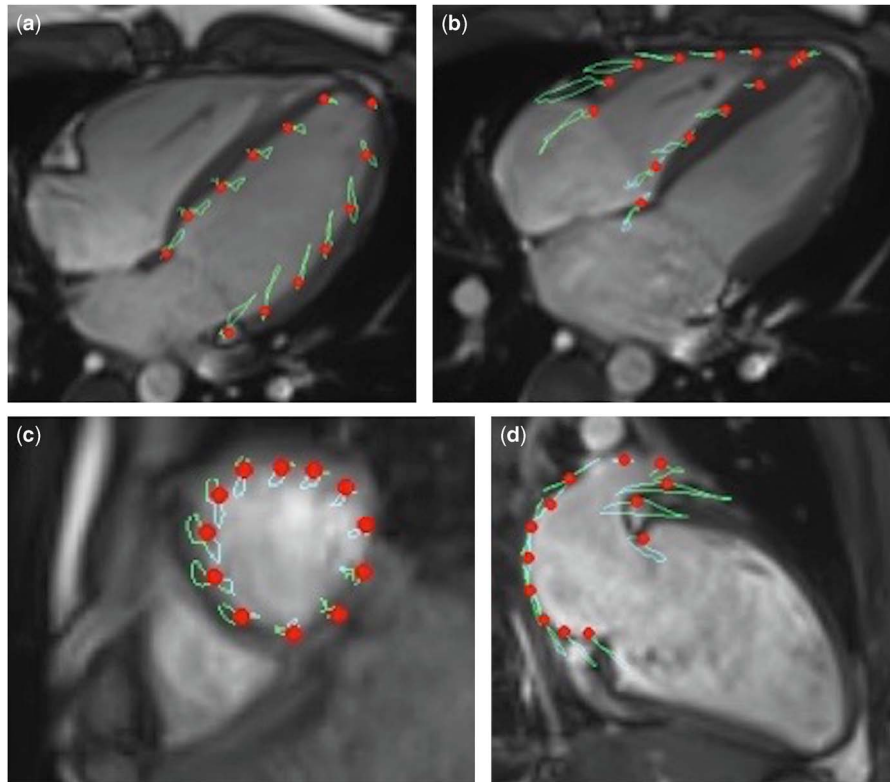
Examples of cardiac MRI feature tracking in a 12-year old soccer player: (a) left ventricle in 4-chamber view (2- and 4-chamber views not shown), (b) right ventricle in 4-chamber view, (c) left ventricle in short axis at the apical level (basal and mid-ventricular slices not shown), (d) left atrium in 2-chamber view.
